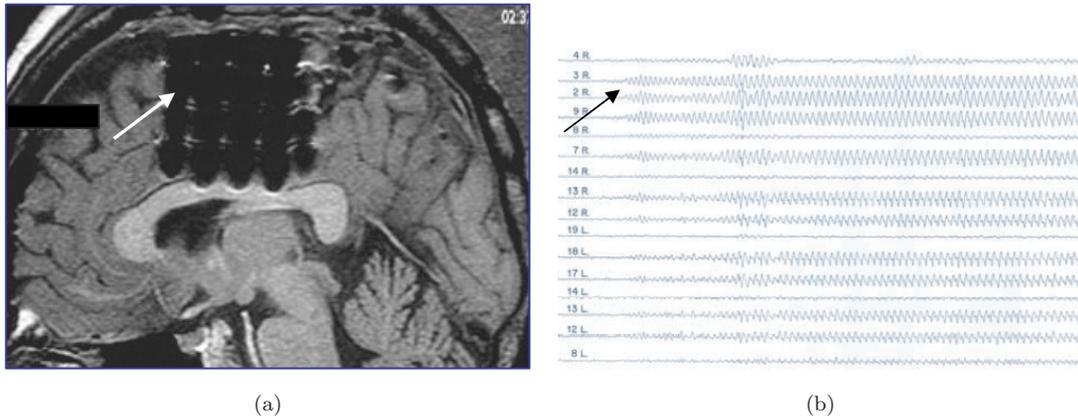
Case 1, patient with supplementary motor cortex epilepsy. 1(a) shows MRI with right 20 contact grid position; white arrow indicates contacts 3 and 9 where ictal activity initiated. 1(b) shows ictal recording, black arrow indicates seizure onset on right grid contacts 3R and 9R.
